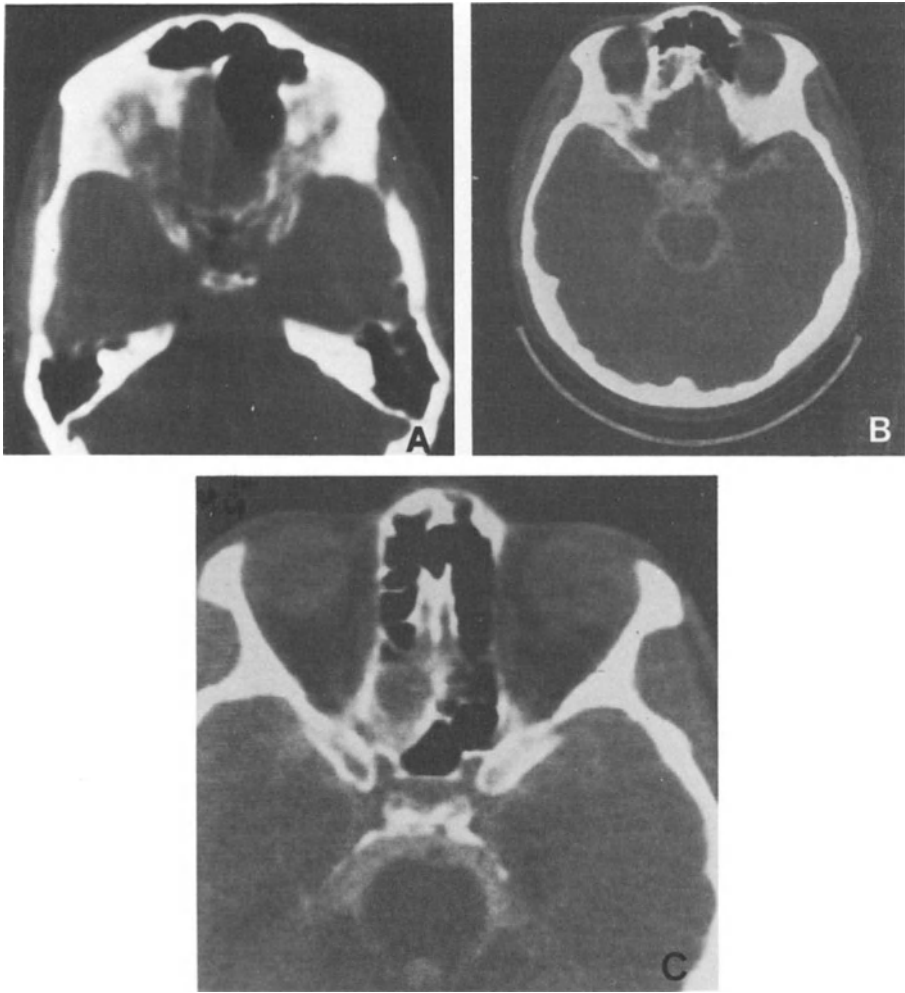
Right ethmoidal CSF fistula.* A) Unenhanced CT, showing a shadowing of the right ethmoidal cells, posteriorly also on the left side. B) and C) Metrizamide CT cisternography. The contrast medium fills the basal cisterns. A pathological accumulation, indicating the fistula, can be seen in the right posterior ethmoidal cells
